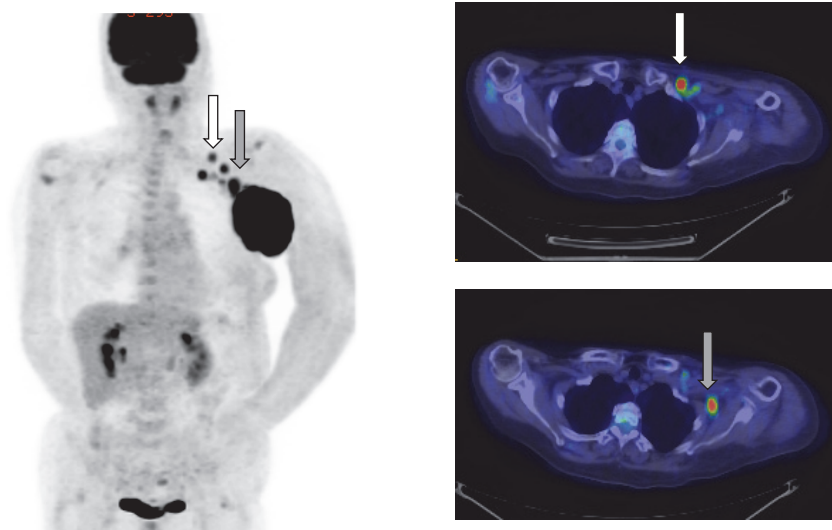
Fluorodeoxyglucose (FDG) positron emission tomography (PET)/CT showing an axillary mass (gray arrow) and an infraclavicular mass (white arrow).
